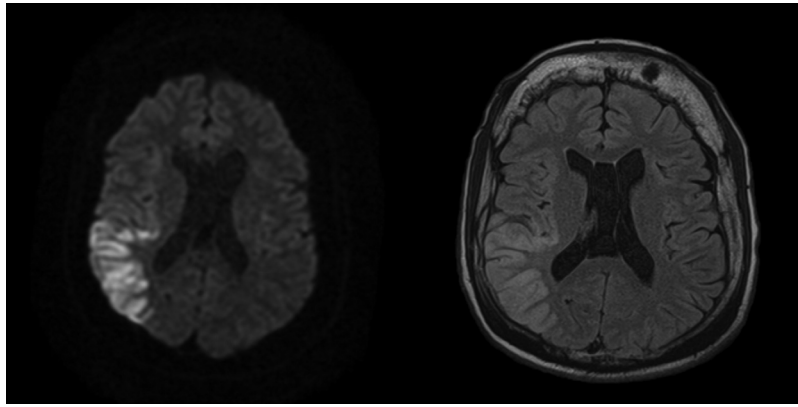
The estimations of infarct and penumbra for RAPID, Sphere, and Vitrea CTP software compared with DWI. For RAPID, infarct and penumbra are represented as pink and green regions, respectively. For Sphere and Vitrea, red and yellow regions indicate infarct and penumbra, respectively. Note the spatial agreement seen between the estimated ischemic regions with follow-up imaging.
